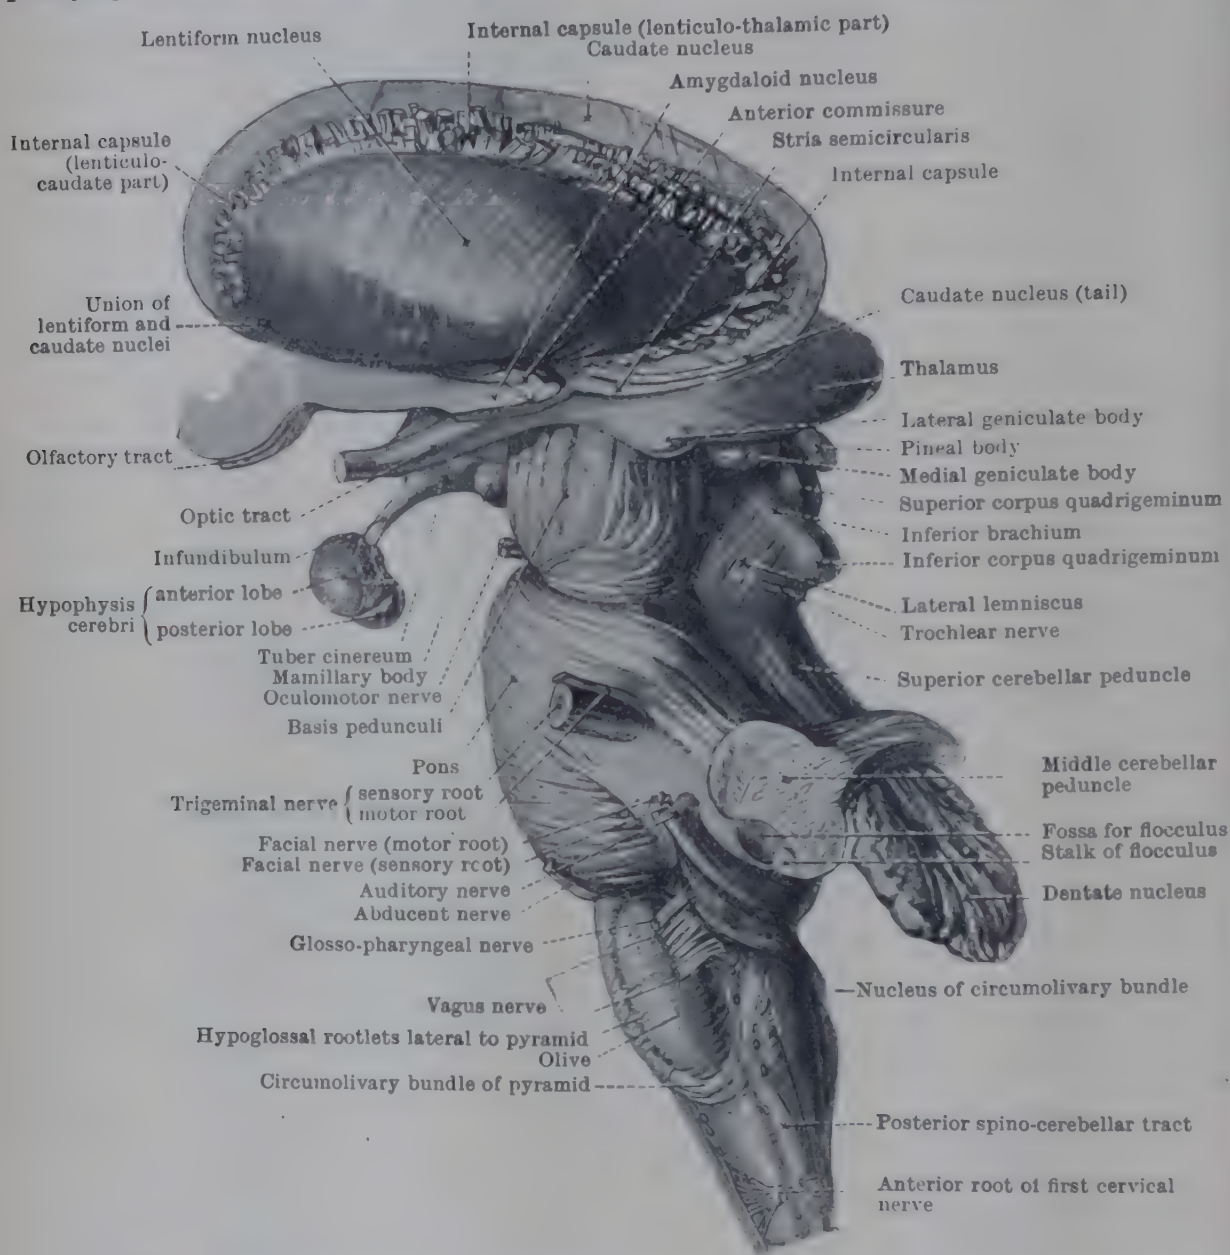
LEFT LATERAL ASPECT OF BRAIN AFTER REMOVAL OF THE CEREBRAL HEMISPHERE (EXCEPT CORPUS STRIATUM) AND THE CEREBELLUM (EXCEPT DENTATE NUCLEUS).
